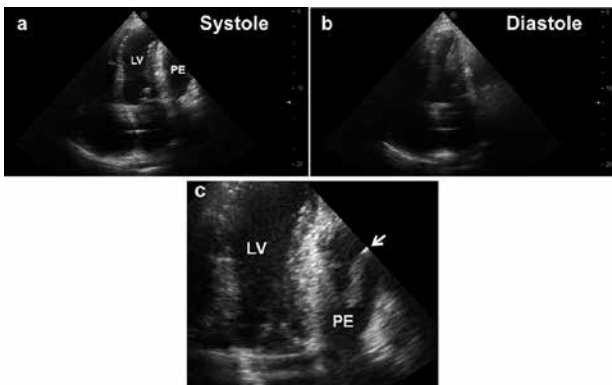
Four alveus section images with the transthoracic echocardiography (a, b). Localized pericardial effusion (PE) is found in a left ventricle (LV) backside. A fibrin deposits are found in a cardiac sac (c).
